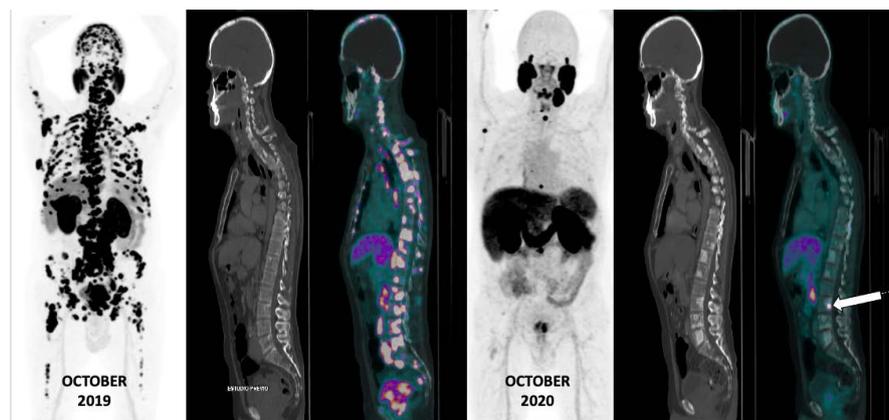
67-year-old male patient with prostate cancer. MIP in the anterior projection of PET/CT with ^{18}F -PSMA performed in October 2019 (PSA 1789 ng/mg) manifest extensive lymph node tumor burden and predominance in bone; window CT for bone and fusion in the sagittal section with multiple uptakes with poor anatomical representation in the spine. In the PET/CT to assess response to treatment one year later, there is a significant decrease in hyper-uptake bone metastases, however the number of osteoblastic lesions (inactive metastases) increased.
